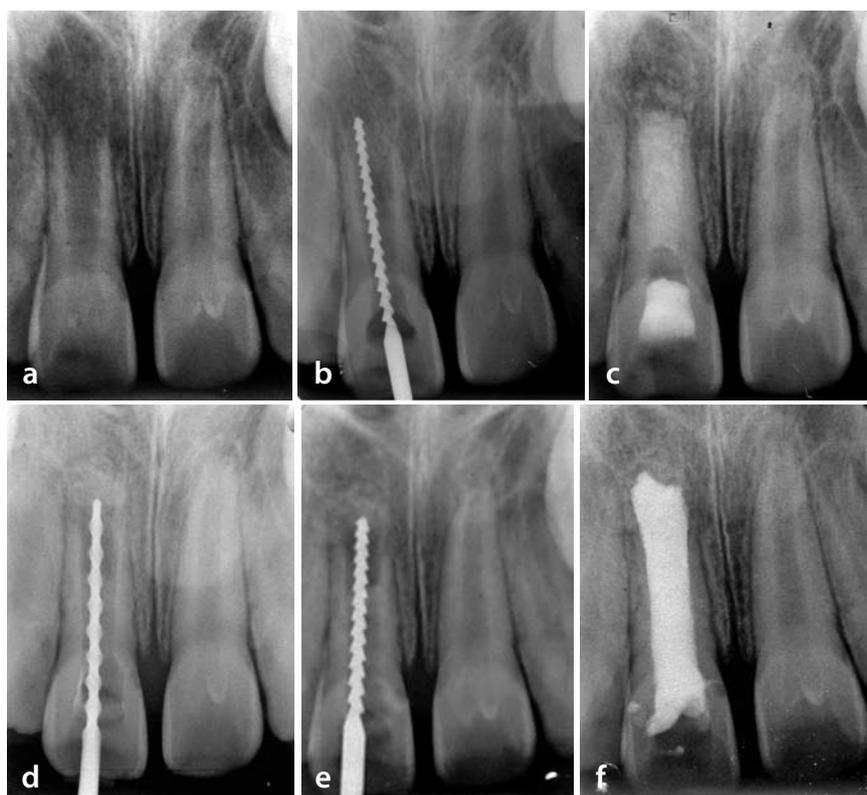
a) a diagnostic radiograph of a traumatized tooth 11 R1/2; b) working length determination; c) a radiographic control of $\text{Ca}(\text{OH})_2$ + HA intracanal medication; d) and e) radiographic and clinical control of apical barrier formation after 3 and 6 months respectively; f) radiographic determination of canal's final filling after 10 months of treatment
